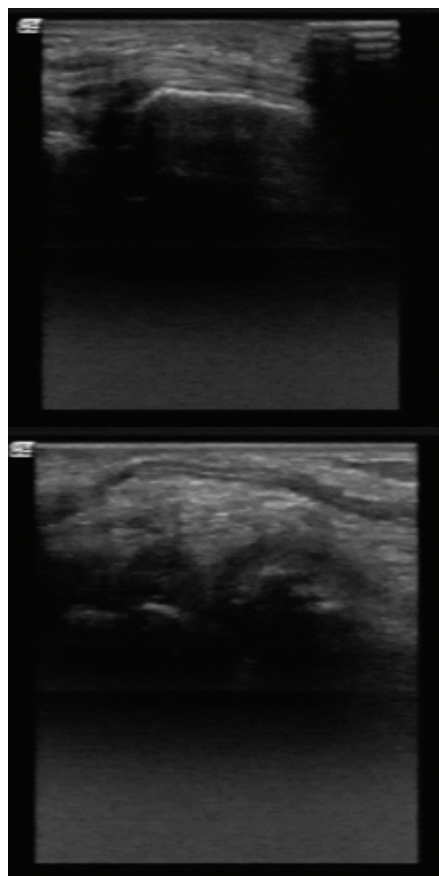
Ultrasound of the right wrist joint of patient P., 74 years old: carpal tunnel syndrome. Synovitis
